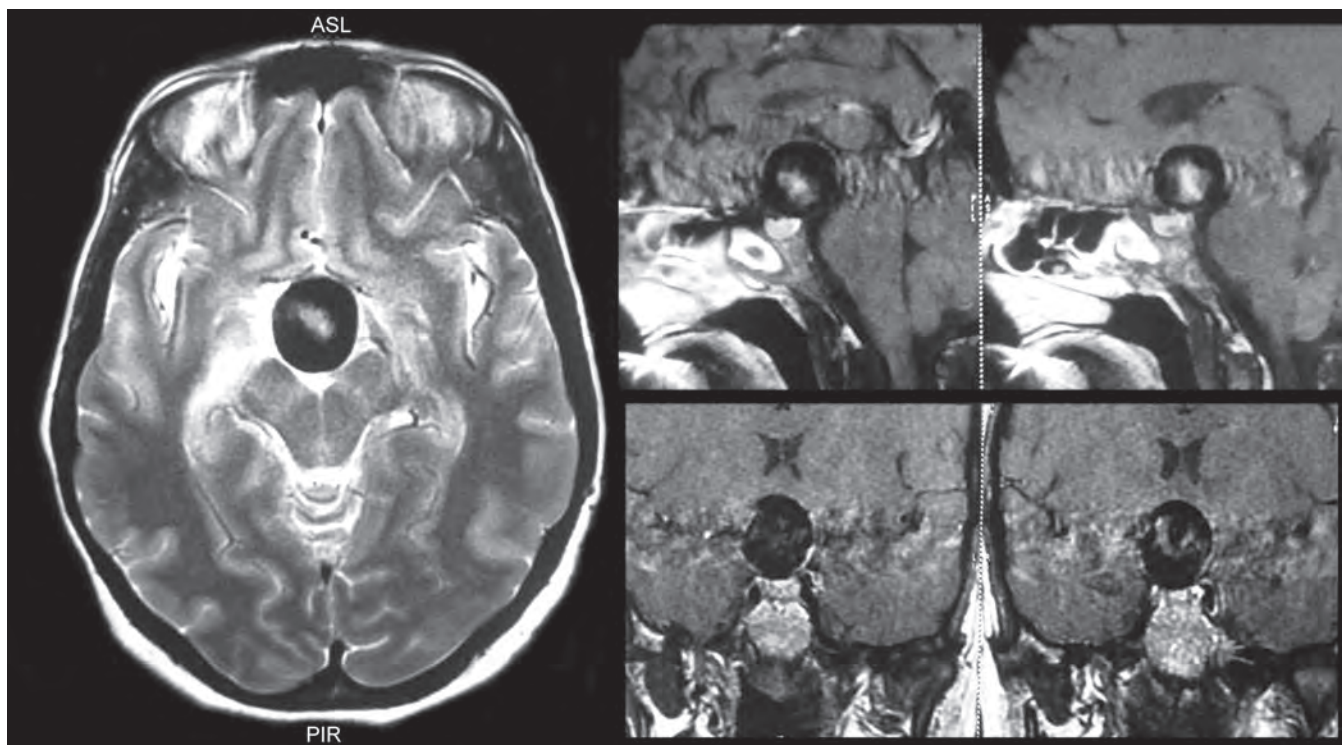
MRI scan of the brain showing large ACoAA in the suprasellar region with an intramural thrombus
